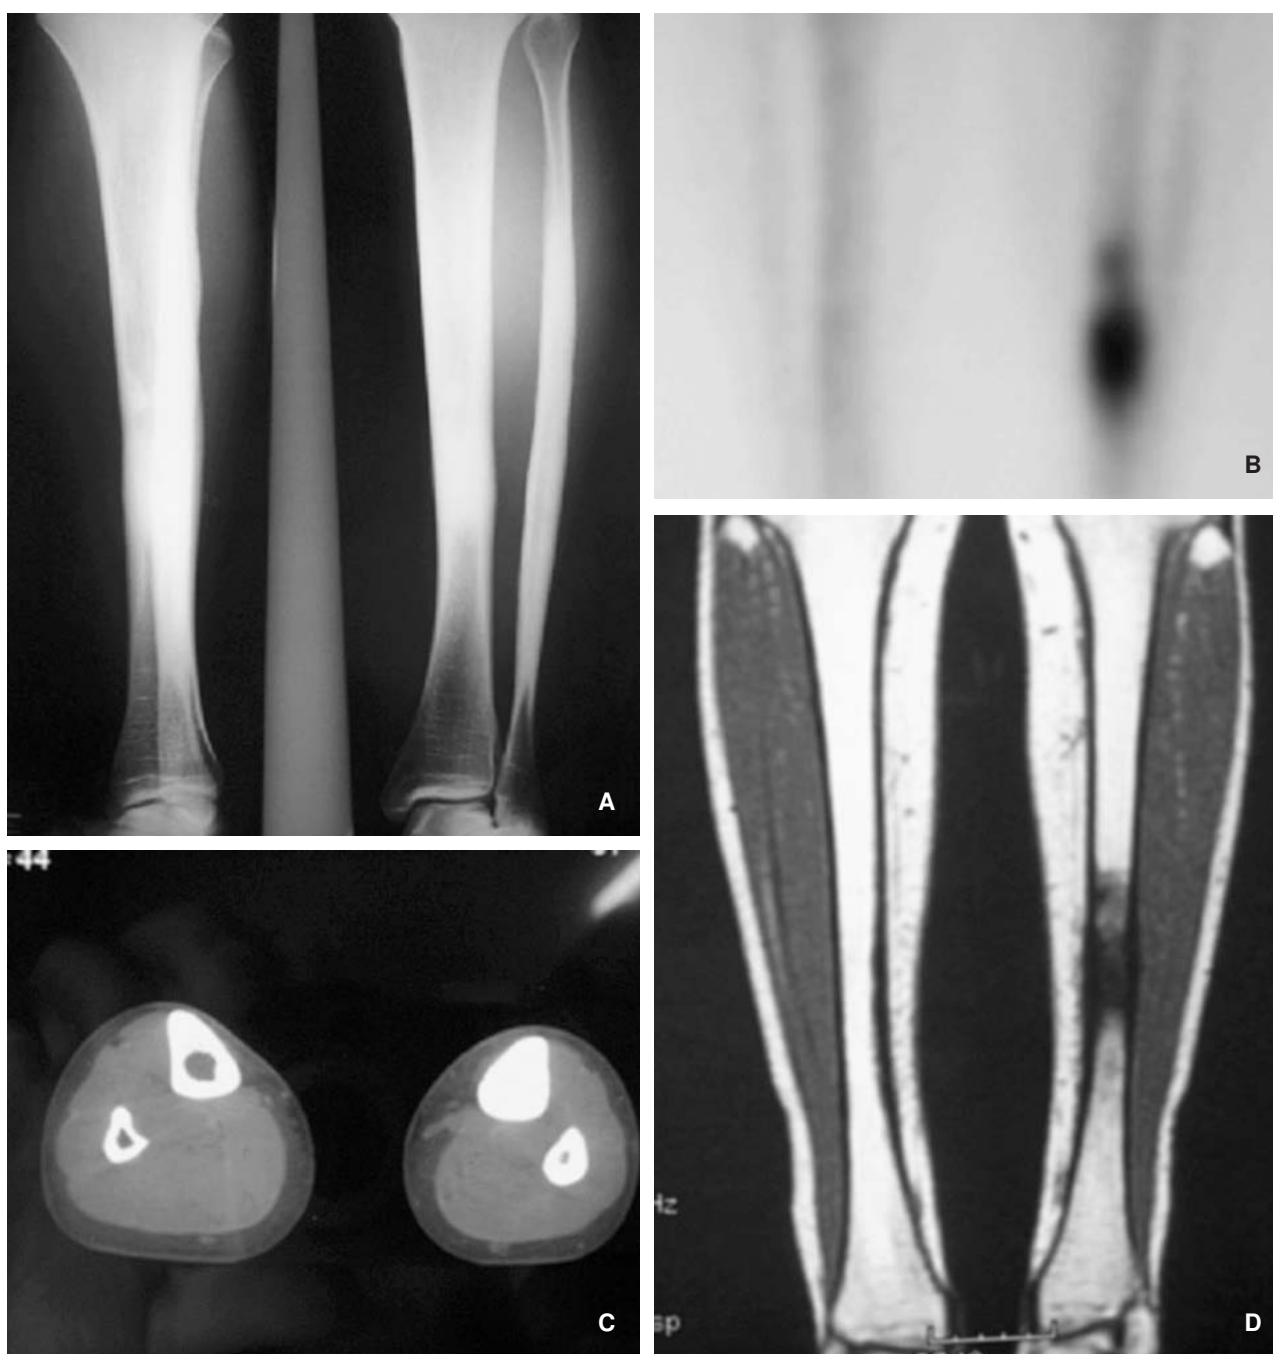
(A) Plain anteroposterior and lateral films of the left tibia and fibula showing the endomedullary cortical thickening (B) Bone gamma-graphy showing intensely increased uptake at the level of the lesion. (C) Computed tomography showing formation of new endomedullary bone that obliterates the medullary cavity. (D) Magnetic resonance image showing periosteal thickening with no involvement of the soft tissues.
